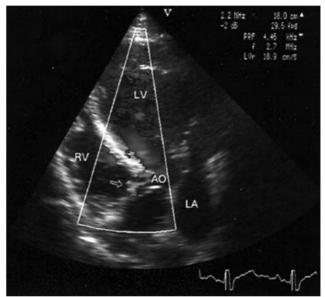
Color Doppler echocardiography showing a jet (arrow) near the right aortic coronary cusp, which looked like a residual ventricular septal defect. LV: left ventricle, LA: left atrium, RV: right ventricle, AO: ascending aorta.
